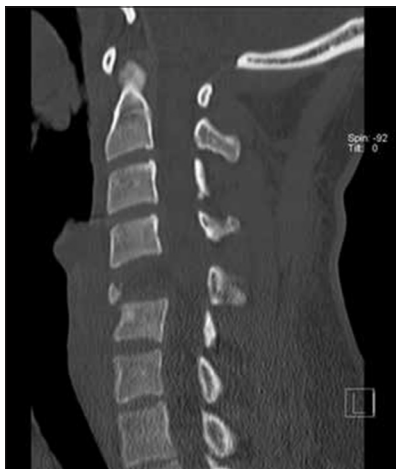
Preoperative sagittal computed tomography of C5 burst fracture
